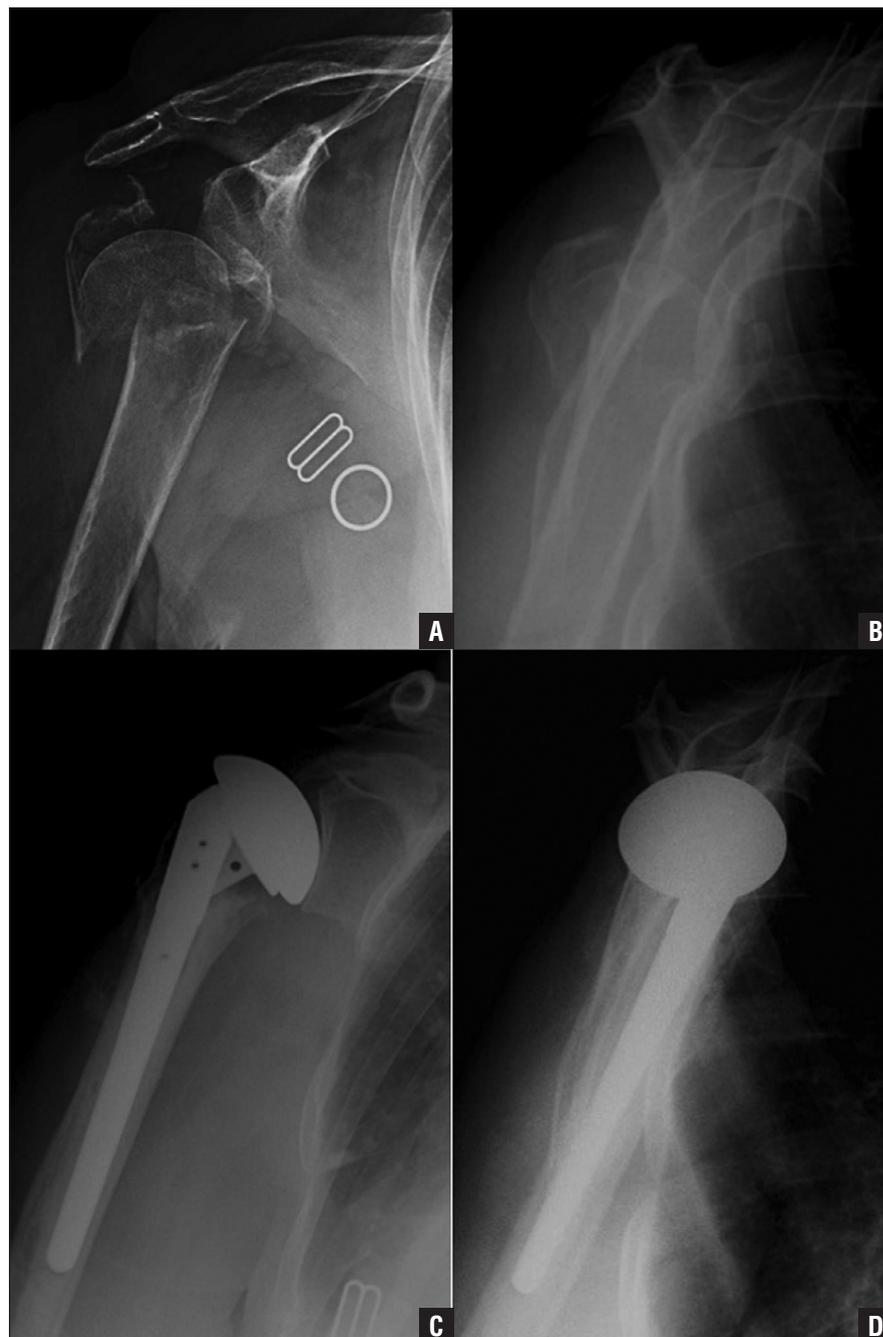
Anteroposterior (A, C) and scapular Y (B, D) radiographs of a displaced and impacted 4-part proximal humeral fracture (A, B) with complete loss of the medial calcar. This injury was treated with a cemented humeral hemiarthroplasty (C, D).
